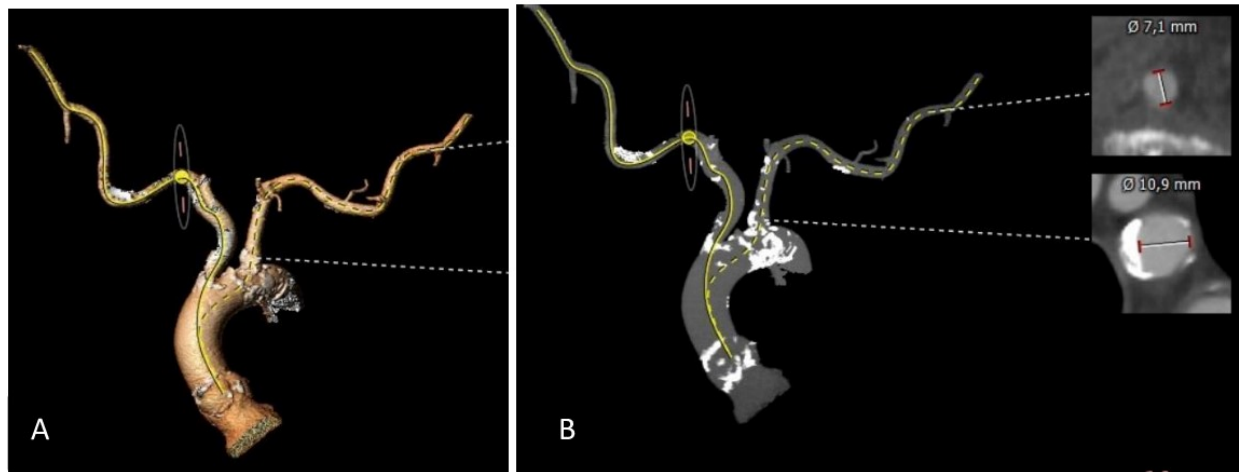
Computed tomography images in preparation for a transaxillary TAVI procedure. (A) Computational rendered image of aortic arch, brachiocephalic trunk and left subclavian artery. (B) Calcifications of the aortic root, arch and ascending aorta including brachiocephalic trunk and left subclavian artery. The calcification is mostly pronounced in the aortic arch and at the ostium of the left subclavian artery with cross-sectional image showing a minimal lumen diameter of 10.9 mm at this level, which is not impeding a trans-axillary access. TAVI, transcatheter aortic valve implantation.
